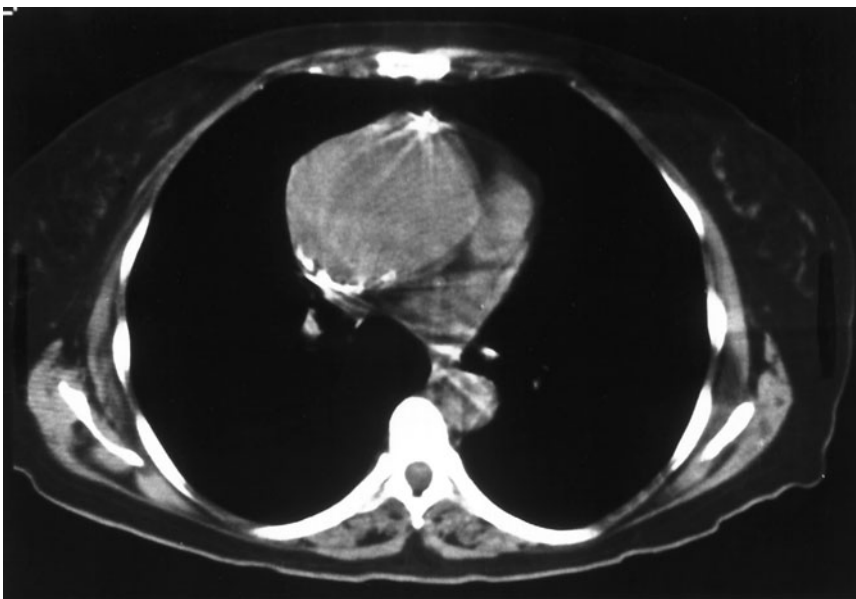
Computed tomographic scan of an 8-cm ascending aortic aneurysm. (Reproduced with permission from Downing SW, Kouchokos NT: *Ascending aortic aneurysm*, in Edmunds LH Jr (ed): *Cardiac Surgery in the Adult*. New York, McGraw-Hill, 1997; p 1163.)
